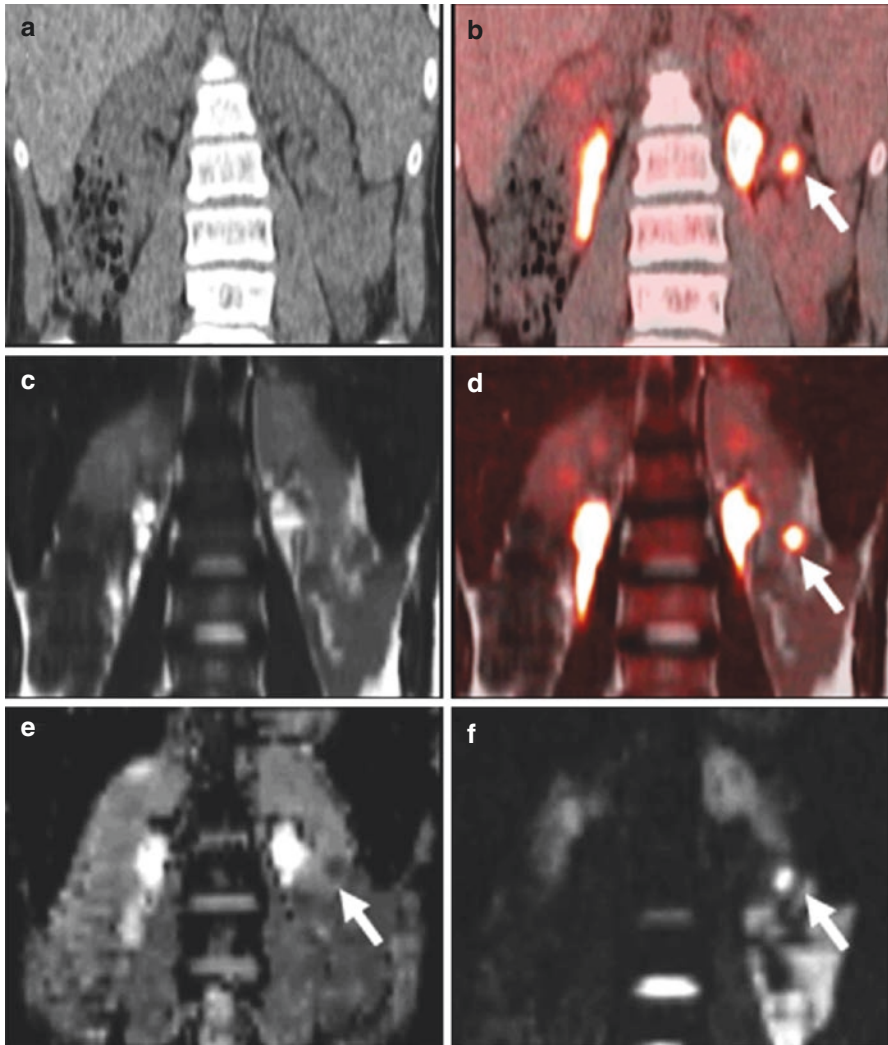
17-year-old male with diffuse large B-cell lymphoma with focal left renal involvement. Restricted diffusion seen on DWI (f, *white arrow*) allowed better identification of the renal lesion and differentiation from excreted FDG in the collecting system. The lesion is not well identified on non-contrast CT (a) or T2 single shot fast spin echo images (c). (a): CT from PET/CT; (b) fused FDG-PET/CT; (c) T2 single shot fast spin echo; (d) fused FDG-PET/MRI; (e)ADC; (f) DWI
